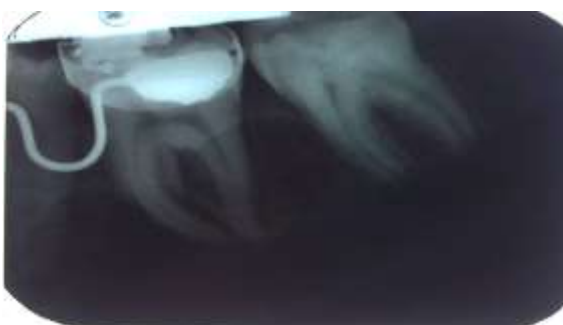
Shows intra-oral periapical radiograph showing well defined radiolucency extending
